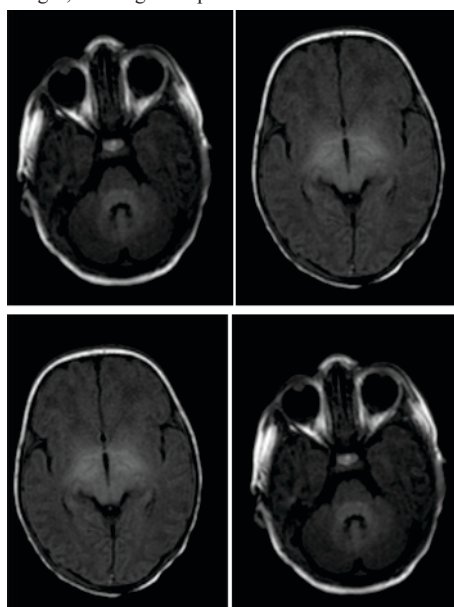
MRI FLAIR images showing symmetrical altered signal intensities in bilateral perirolandic regions, putamen and thalamus & also in the mid brain, pons and upper medulla
